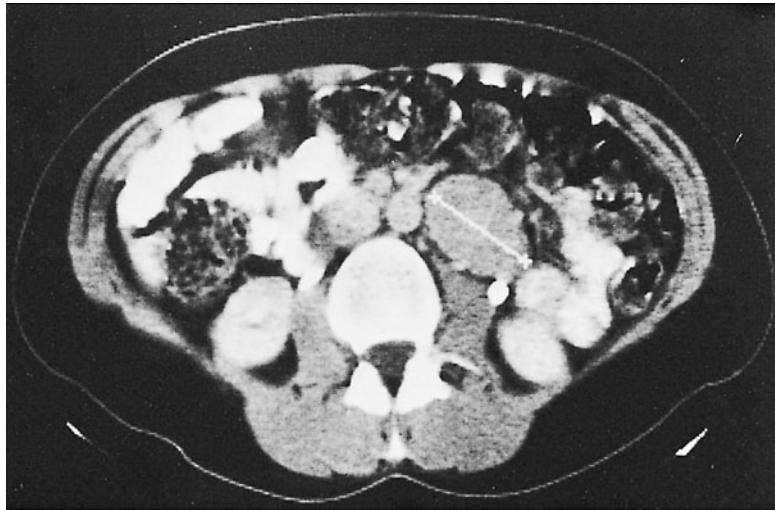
Left infrarenal paraganglioma, CT scan. (Reproduced, with permission, from Greenspan FS, Gardner DG. *Basic and Clinical Endocrinology*, 7th ed. New York: McGraw-Hill, 2004: Fig. 11-9.)
